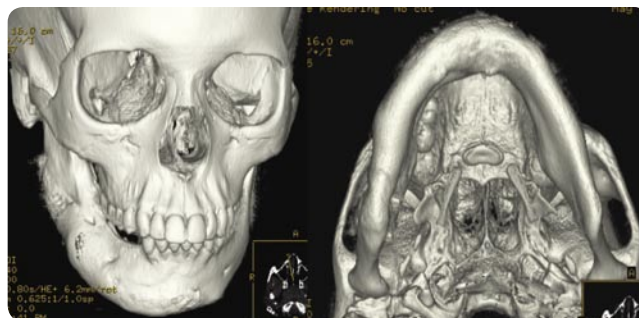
Postoperative 3-D CT scan showing mandibular reconstruction.
